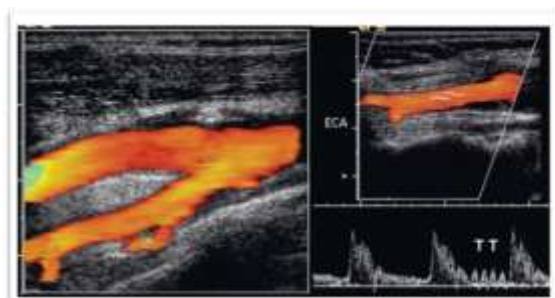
Normal ECA. A. Color Doppler ultrasound of CCA bifurcation demonstrating two small arteries arising from the ECA. B. Spectral Doppler shows the anticipated serrated (sawtooth) flow disturbance from the TT.
